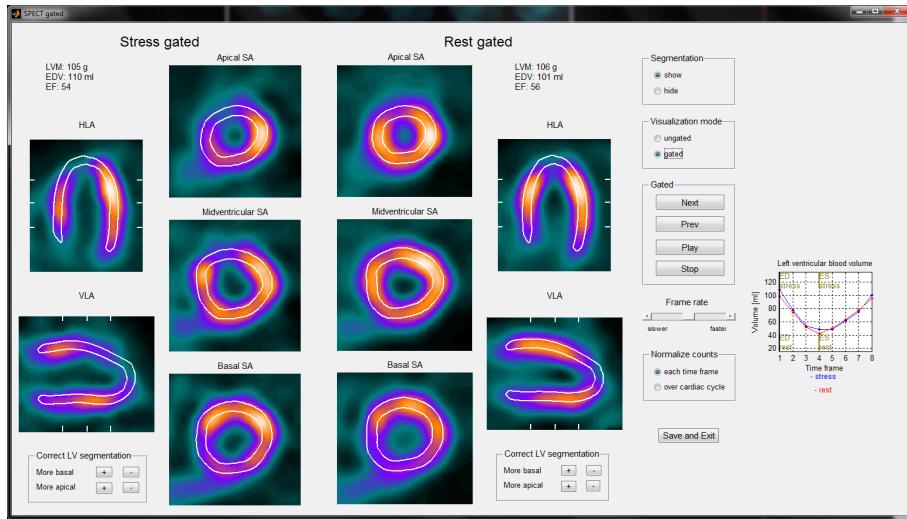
Graphical user interface of the 2 dimensional visualization for SPECT images.
